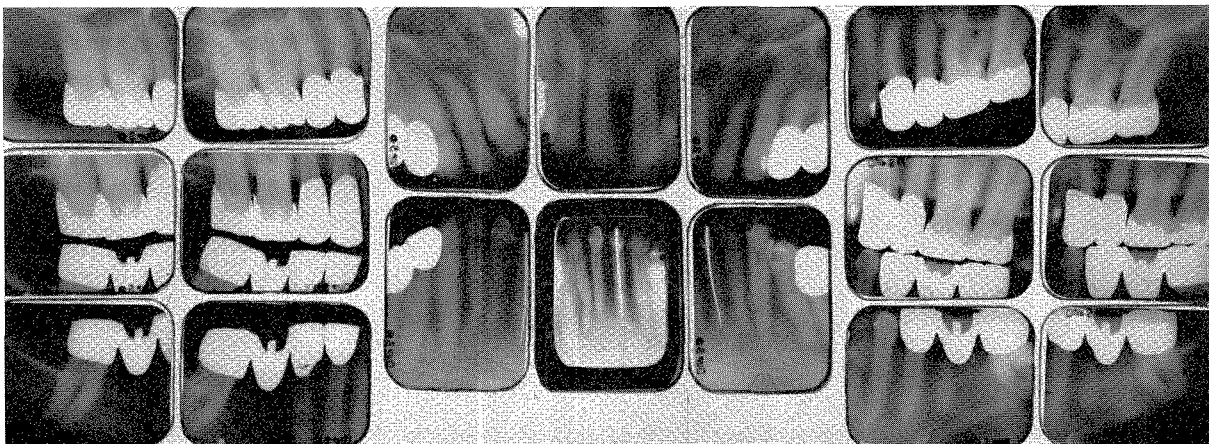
Roentgenograms taken in 1962. This was nineteen years after the case was completed. The structures are excellent.
